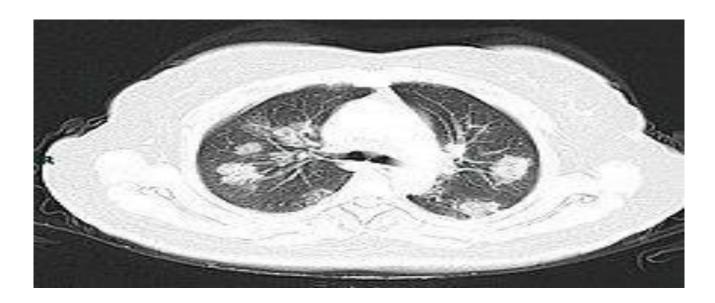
CT scan of a person with COVID-19 shows lesions (bright regions) in the lungs.
